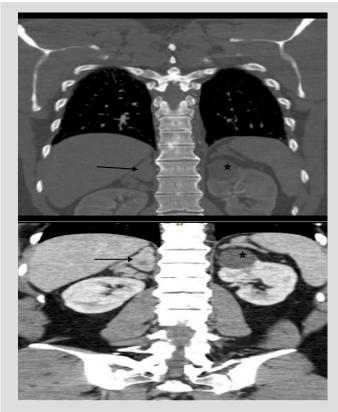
Initial CT of the chest showing incidental findings of enlarged adrenal nodules and a left renal cyst with a left nodular appearing adrenal gland. A CT scan performed on a follow-up visit showed persistent adrenal enlargement. Adrenal enlargement on both images is marked by right arrows and the left renal cyst is marked by star
